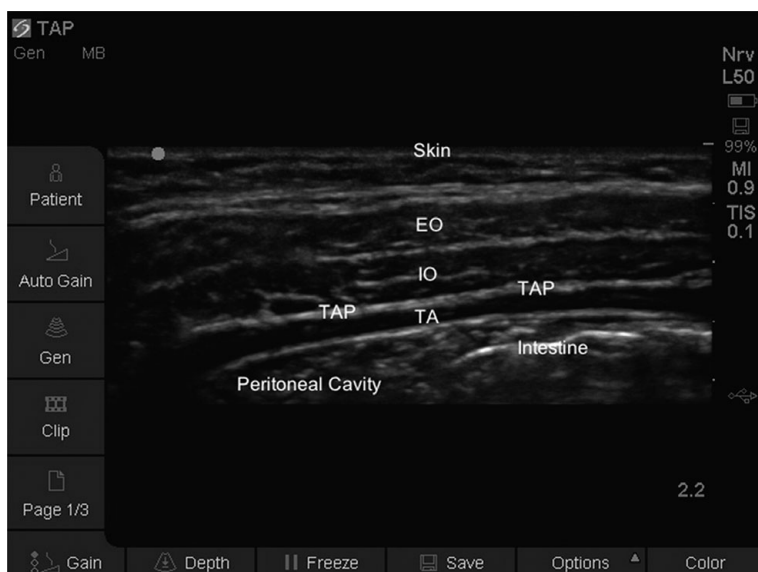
Ultrasound image of transversus abdominis plane block. Reproduced with permission from Mannion S, Iohom G, Dadure C, Reisbig MD, Ganesh A (eds.) 2015. *Ultrasound-Guided Regional Anesthesia in Children*. Cambridge, UK: Cambridge University Press
